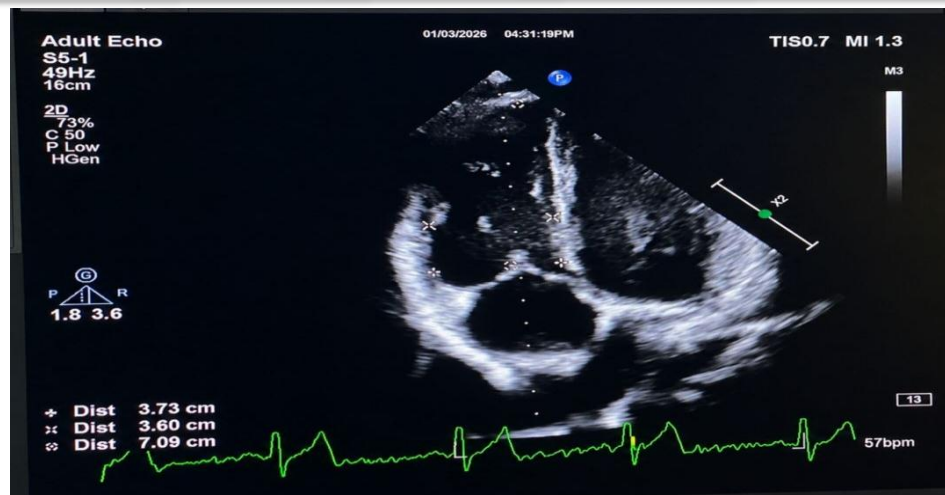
Measurement of Right ventricular dimensions (basal , mild and length) In RV-focused apical four-chamber view at end-diastole.
